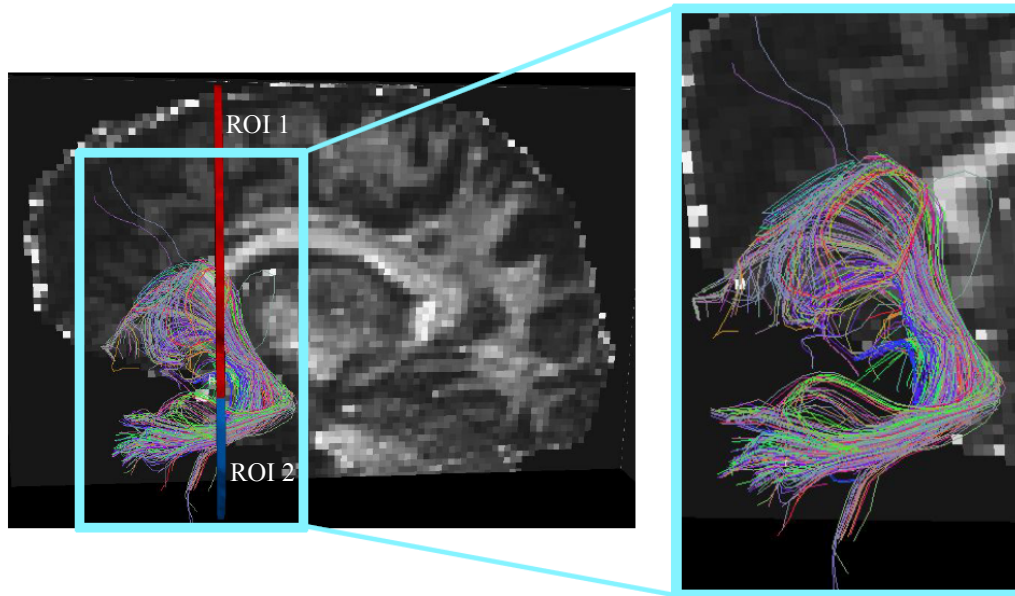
Example tractography image of uncinus fasciculus (UF) in left hemisphere of sagittal plane in sample DW-MRI image. Regions of interest (ROI 1 in red; ROI 2 in blue; shown in image on left) were placed in coronal planes of DW-MRI white matter reconstructions in TrackVis software to isolate the UF. Image on the right depicts a close-up of a typical hook-shaped bundle of UF tracts. Different colors in images represent directionality of diffusion in the individual white matter tracts.
